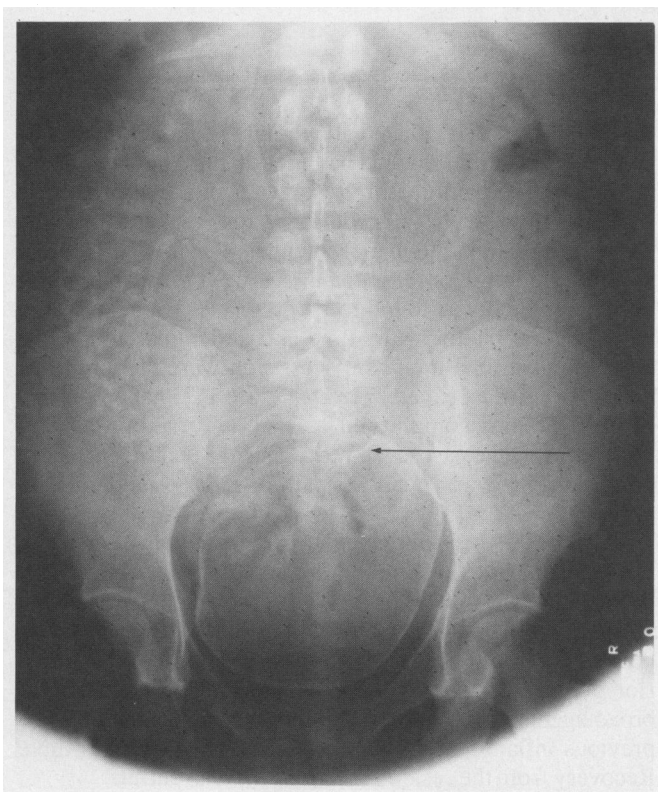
A pelvic x-ray film taken in March 1980 shows a gravid uterus at term and an intrauterine device in the right pelvic area.
